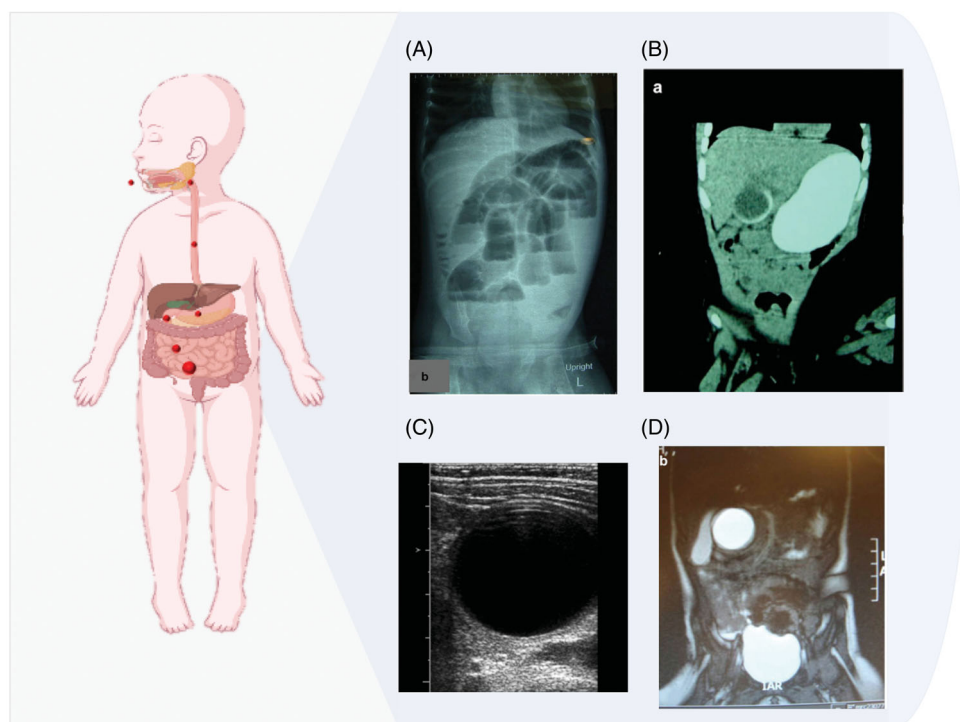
Proposed mechanism of SAPs bead-induced bowel obstruction in children (created with Biorender.com). Young children ingest the SAPs beads in their dried (or not fully hydrated) state – i.e., when their diameter is of the order of a few millimeters, assuming that rounded objects larger than 25 mm in diameter are generally less likely to pass the pylorus, especially in young children [48, 49]. Then, the SAPs beads gradually swell in the small bowel and cause the obstruction. (A) Abdominal X-ray (erect) showed multiple air-fluid levels [16], (B) Abdominal CT scan with IV and oral water-soluble contrast revealed cystic structure in the 1st and 2nd part of the duodenum with surround contrast widening the lumen indicating intraluminal lesion (duplication cyst) [16], (C) Abdominal MRI revealed large well-defined fluid intensity signal cystic lesion in the right upper abdomen $3 \times 3 \times 3.3$ cm located in the right subhepatic region [16], (D) Ultrasound image revealing the fluid-filled bead, measured at $3.8 \times 3.1 \times 3.1$ cm. Dilated loops of the small bowel were identified proximal to this structure [3]. (All these images have been reproduced with permission of the publisher through the Copyright Clearance Center's RightsLink® service. (A) refers to the 1-year-old child from the report by Al Saied et al. and corresponds to part b of Figure 2, the caption has not been modified [16]; (B) and (D) refers to the 9-month-old child from the report by Al Saied et al. and corresponds to parts a and b of Figure 1 [16], the captions have not been modified; (C) refers to the case reported by Moon et al. and corresponds to Figure 2, the caption has not been modified [3]).
